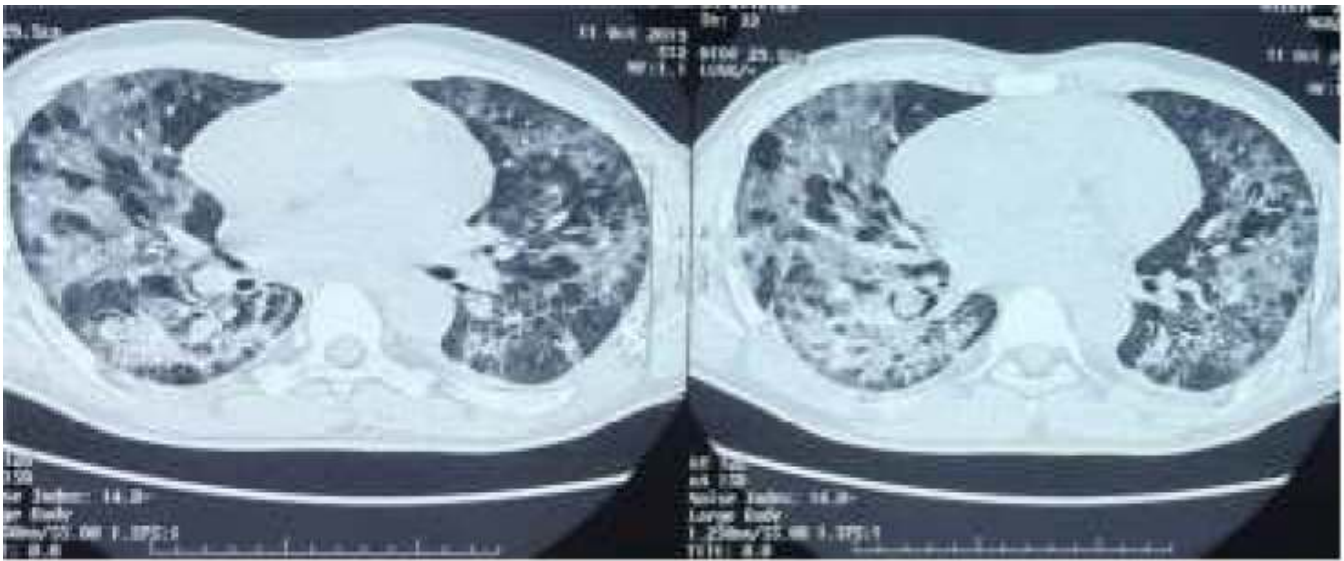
2 HRCT thorax showing geographic ground glass opacities with interstitial thickening (crazy pavement appearance)
